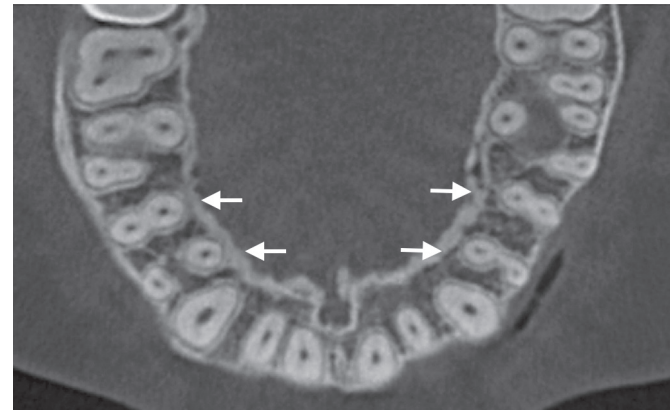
CBCT axial view at mid-root level showing all maxillary first and second premolars have 2 canals (arrows)
